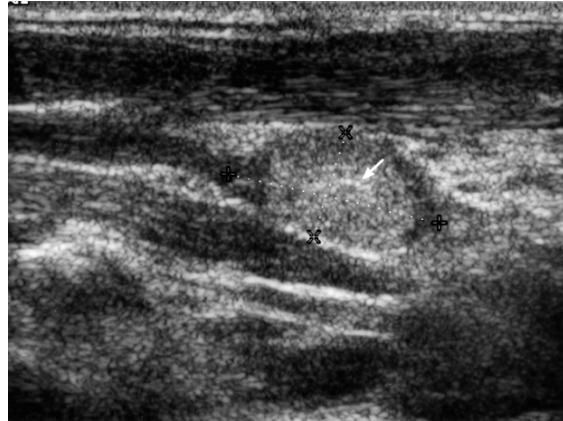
Sonogram showing a longitudinal scan of a hyperechoic metastatic node from papillary carcinoma of the thyroid (calipers). Note the punctate calcification within the lymph node which is common in metastases from papillary carcinoma of the thyroid.
